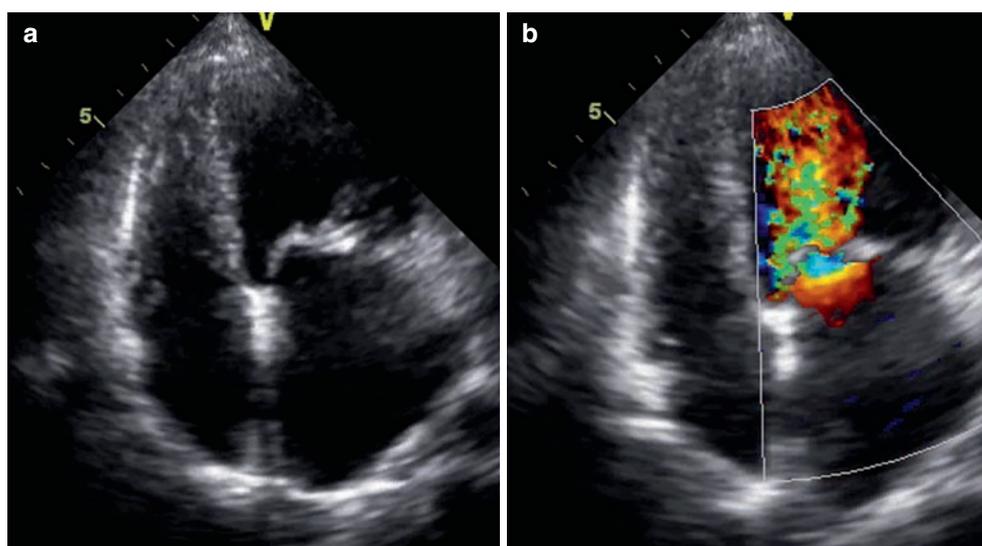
Degenerative (calcific) mitral valve stenosis. (a) Apical 4-chamber view (diastole) showing the thickened and calcified base of the leaflets. (b) Colour Doppler image showing increased transvalvular velocity. (c) Mean gradient approximating 5 mmHg at a heart rate of 60 beats/min
